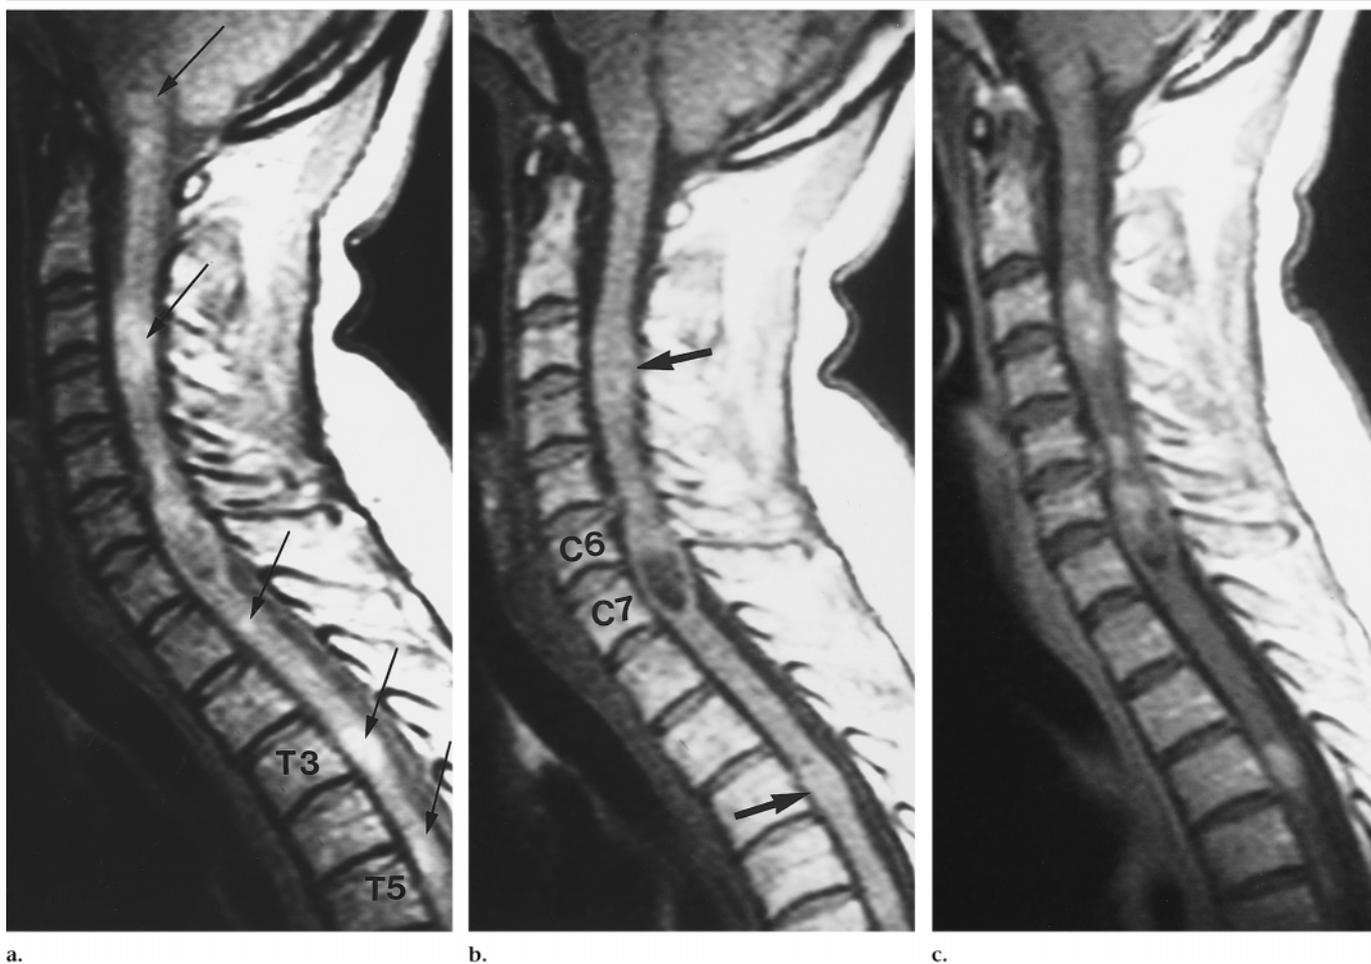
(a) Sagittal intermediate-weighted MR image (2,500/20) of the cervical spine. Several hyperintense tumors (arrows) are present at the level of the medulla, C3–C4, C6 to C7, T1, T3, and T5. The tumor at the C6–C7 level is large and partially cavitary, and it produces cord engorgement. Less obvious cord engorgement is also caused by the tumors at the C3–C4 and T3 levels. (b) Sagittal nonenhanced T1-weighted image (417/16) clearly demonstrates the cavitary tumor at the C6–C7 level. Two of the solid tumors at the C3–C4 and T3 levels appear slightly hyperintense with respect to the normal cord (arrows). (c) Sagittal contrast-enhanced T1-weighted image (417/16). All intramedullary tumors are enhanced.
